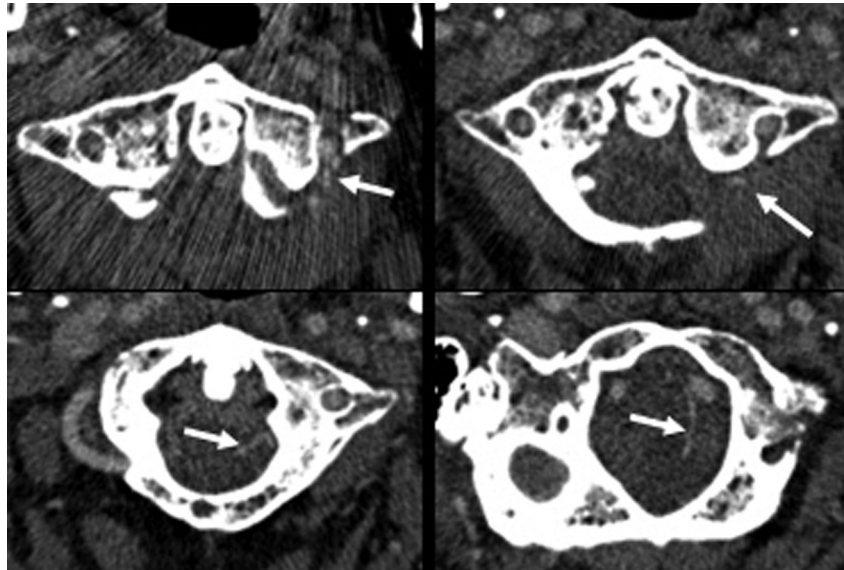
Computed tomography angiogram demonstrating the course of the posterior inferior cerebellar artery that begins between the C1 and C2 foramen, following the C2 nerve root that then enters intradurally and progresses cephalad toward the cerebellum (arrows).
